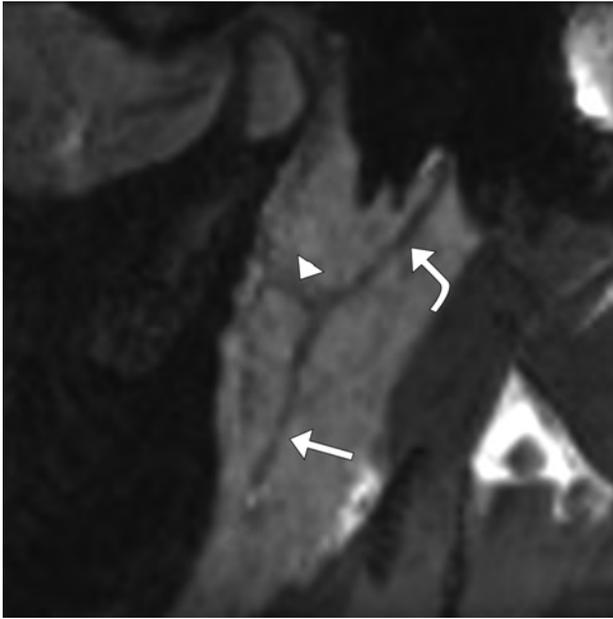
Representative sagittal-oblique CISS minimum intensity projection MR image shows the visible course of the facial nerve trunk (curved arrow) from the stylomastoid foramen to the distal aspects of the temporofacial (arrowhead) and cervicofacial (arrow) trunks.
